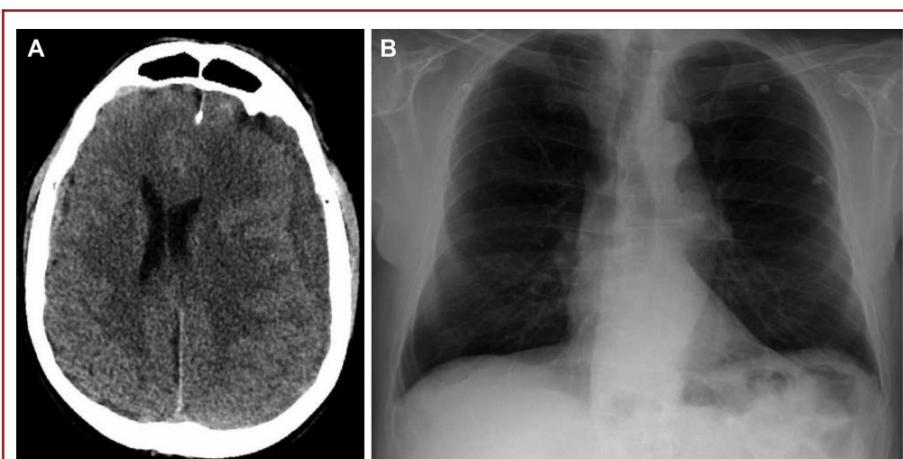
A and B, Head CT scan, axial view: pre- and postoperative CDSH. C, CXR showing bilateral and diffuse IP.FIGURE 2. A, Head CT scan, axial view: bilateral CSDH. B, CXR showing bilateral and diffuse IP. C and D, MMA embolization procedure.
